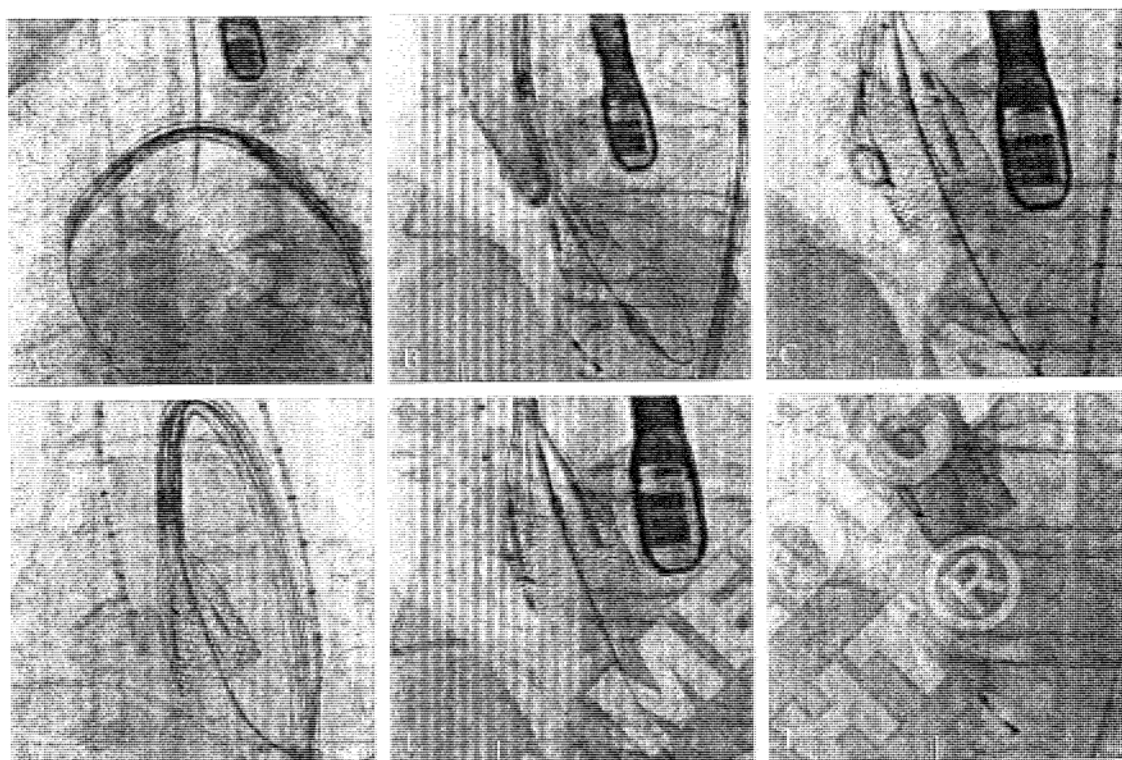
SADRA Lotus Valve Deployment Case 4 in the REPRIS I Trial. A) Delivery of the valve across the aortic arch; B) unsheathing the valve by counter-clockwise rotation of the handle. Maintaining the tantalum marker at the midpoint of the native leaflets; C) reaching towards full expansion the valve was deemed too low; D) the Valve was partially resheathed by clockwise rotation of the handle; E) the valve was positioned optimally with the tantalum marker at the midpoint of the native leaflets; F) following full angiographic and echocardiographic assessment the valve was released.
